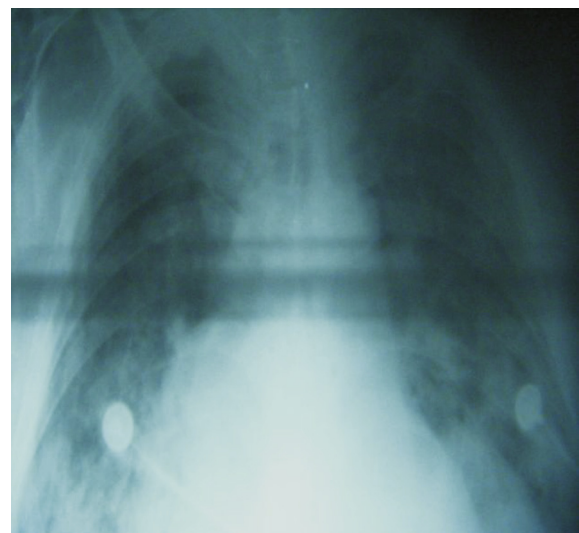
A chest X-ray on admission showing a left paracardiac mass about 6 cm × 3 cm in diameters.
